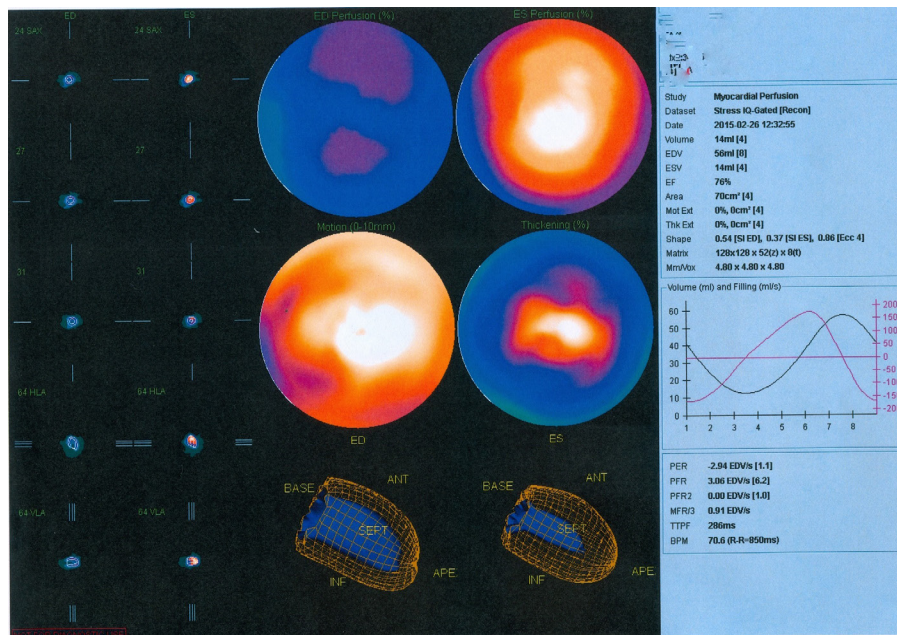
A stress C-SPECT scan of a female patient aged 69 who presented with chest pain and intact coronary arteries
